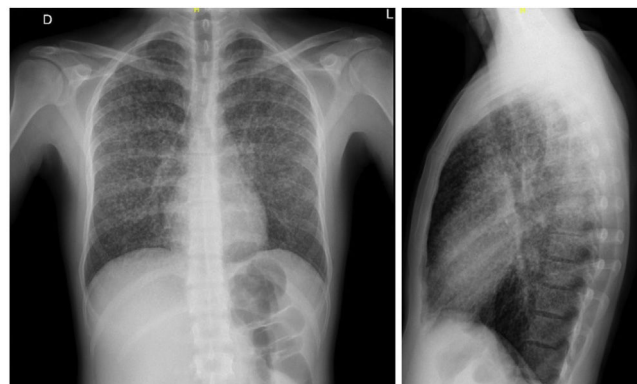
Posterior-anterior and lateral chest X-ray showing a universally distributed micronodular interstitial pattern.
